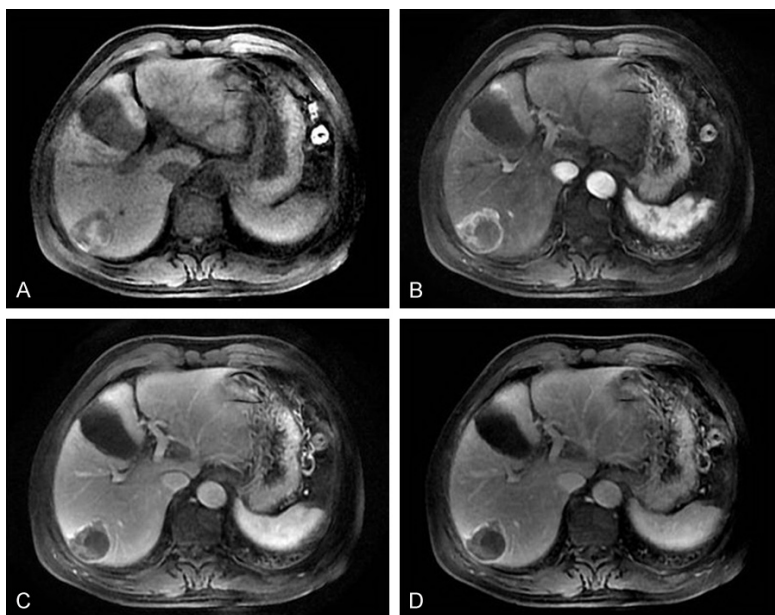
A hepatocellular carcinoma of the focal extranodular type in a 61-year old man confirmed to be MVI-positive by pathologic analysis. A T1-weighted image (A) shows a hyperintense area in the hypointense tumor (confirmed necrosis and hemorrhage on pathologic analysis). T1-weighted images at arterial phase (B), portal-venous phase (C), and equilibrium phase (D) show arterial phase enhancing and washout on portal-venous phase and equilibrium phase and focal outgrowth from the main nodular lesion, protruding into the normal parenchyma.
